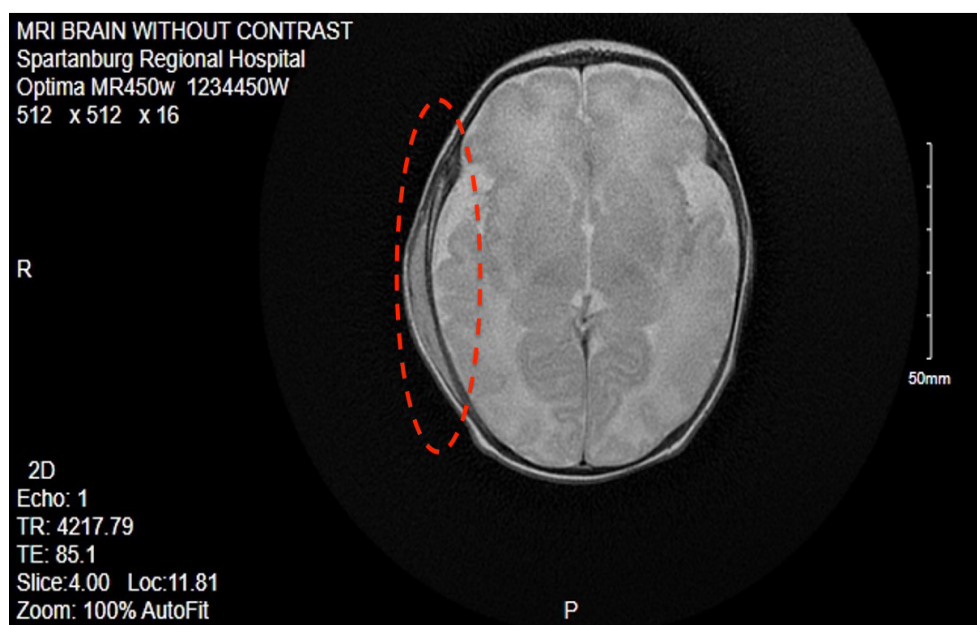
MRI revealing evidence of cephalohematoma.
